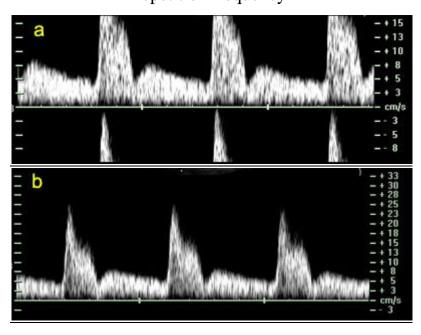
(a,b): Example of aliasing and correction of the aliasing. (a) Waveforms with aliasing, with abrupt termination of the peak systolic and display this peaks bellow the baseleineSonogram clear without aliasing. (b) Correction: increased the pulse repetition frequency and adjust baseline (move down)
